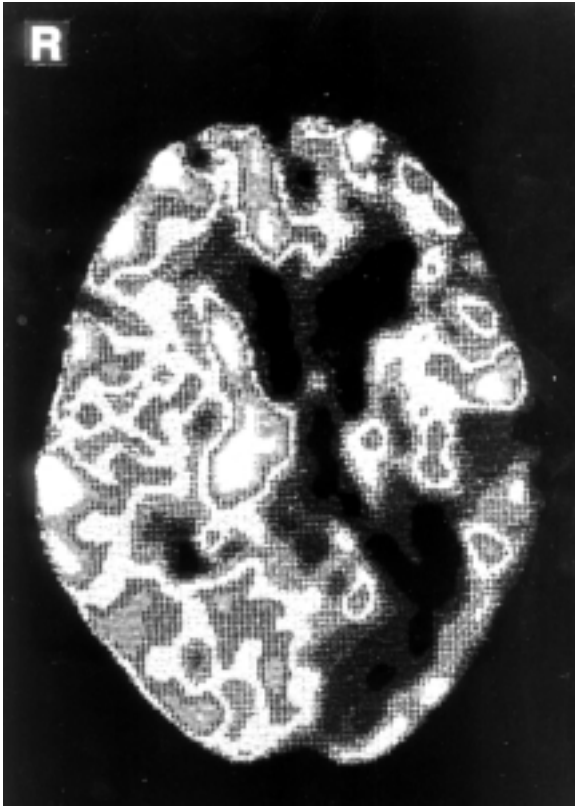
Evaluation of cerebral blood flow using Xe-CT.
